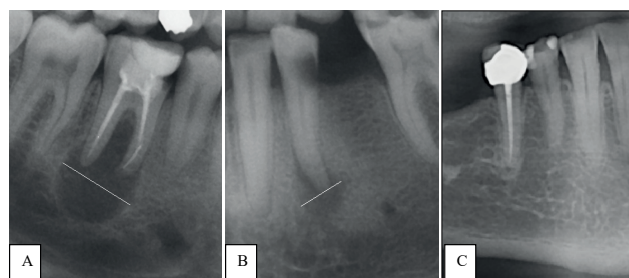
A. S3R3D2 Cropped panoramic radiographic image of a lesion larger than 5 mm involving both roots and extending into the furcation B. S3R1D1 Cropped panoramic radiographic image of a lesion larger than 5 mm involving a single root. C. SORODO Cropped panoramic radiograph image of healthy periapical tissues.
